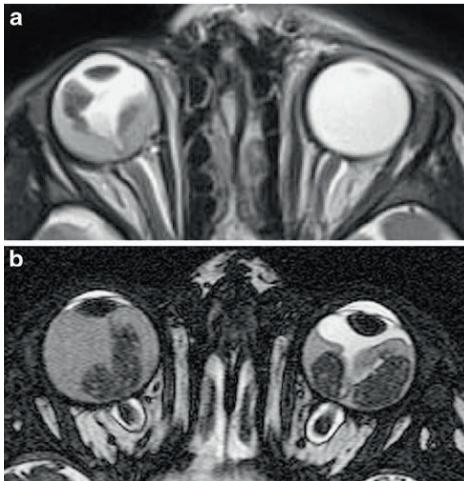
a Thin-slice transaxial T2-weighted (TR/TE, 4,430/102 ms; section thickness, 2 mm) image demonstrates retinoblastoma of the right eye with secondary retinal detachment. b Transaxial constructive interference steady-state (TR/TE, 14/7 ms) image of bilateral retinoblastoma with secondary retinal detachment. Notice the shallow anterior chamber of the right eye, a sign of increased intraocular pressure
